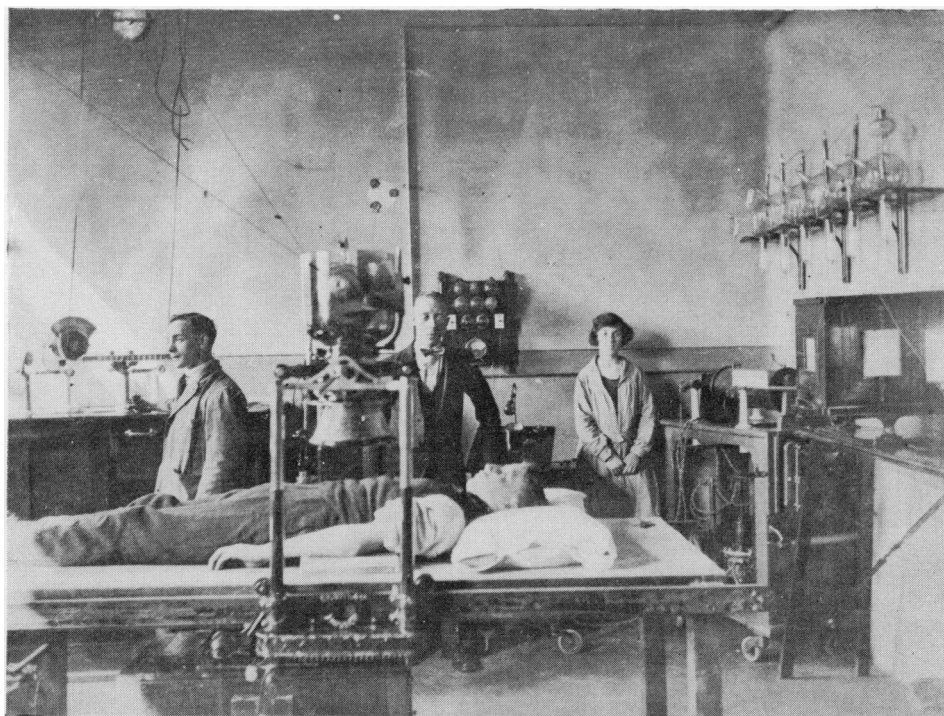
Royal Victoria Hospital. Only X-ray Room in 1920*
